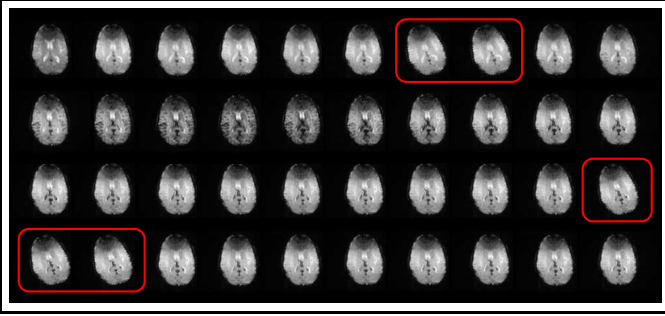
DSC-MRI time series. It shows central slices of 40 volumes from top to bottom and left to right. Here, central slices corresponding to non-bolus phase are from 1 to 9 and from 21 to 40. -15° rotation is added to volumes 7, 8, 30, 31 and 32 respectively and their corresponding central slices are shown in red boxes.
